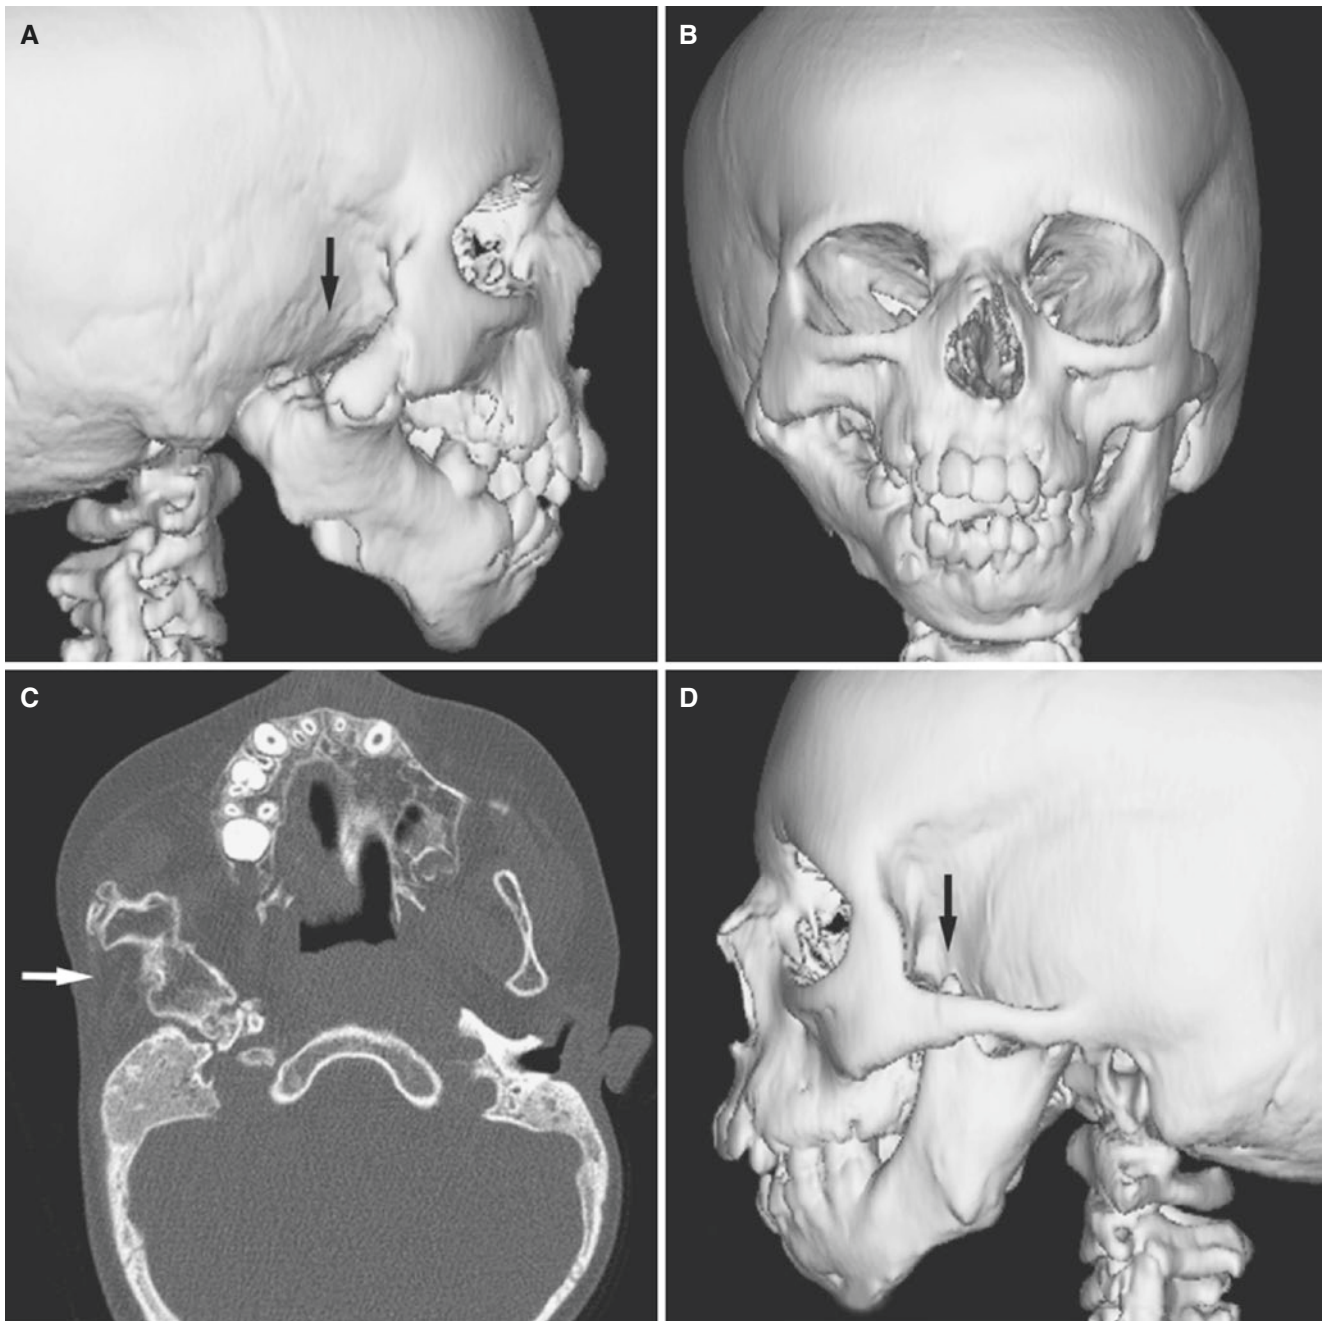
Facial asymmetry, unilateral ankylosis, and absent zygomatic arch; 8-year-old. (A) 3D CT image, lateral view of right side, shows absent zygomatic arch (*arrow*) and thus no glenoid fossa; ankylosis between mandible and remaining abnormal zygomatic bone. (B) 3D CT image, en face view, shows mandibular asymmetry and open
